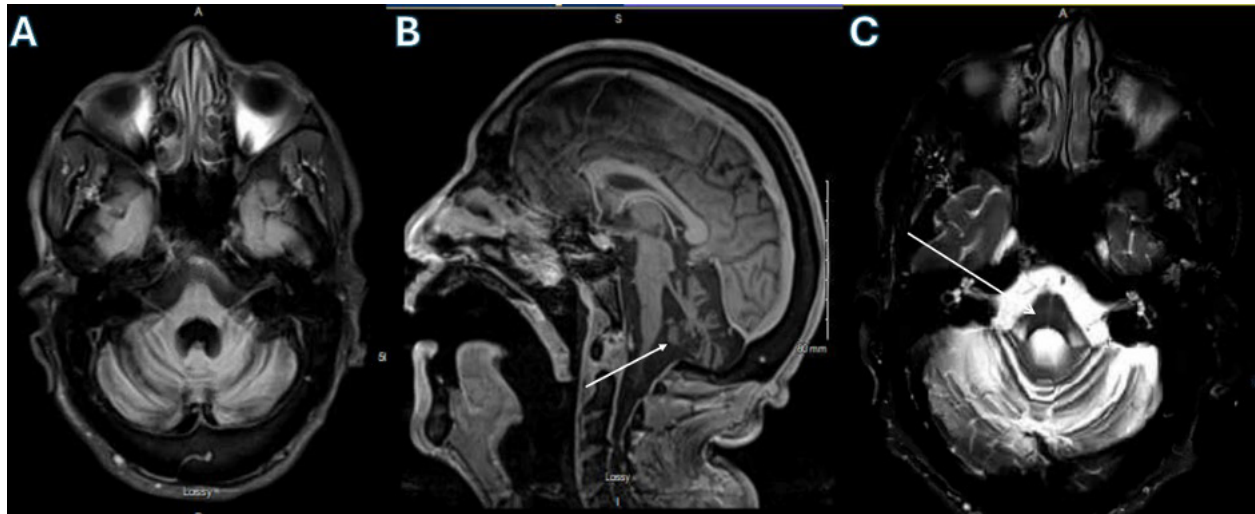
A. MRI FLAIR of the brain in the axial section at the level of the pons showing generalized atrophy of the cerebellum. B. T1 sequence with contrast at the midline level showing severe atrophy of the cerebellum (white arrow) as well as the brainstem structures. C. MRI T2 sequence of the brain shows the hot cross bun sign (white arrow).
